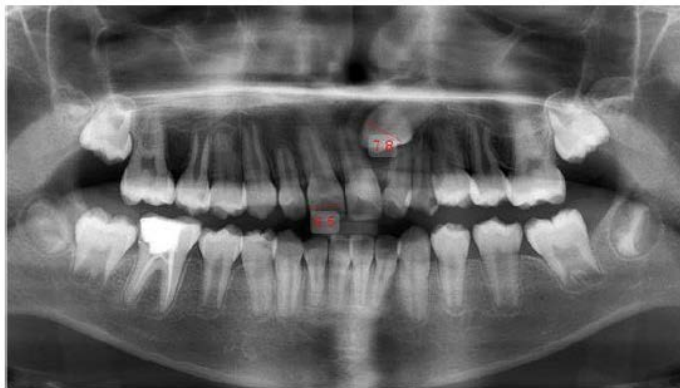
Panoramic radiograph showing localisation with Magnification index
